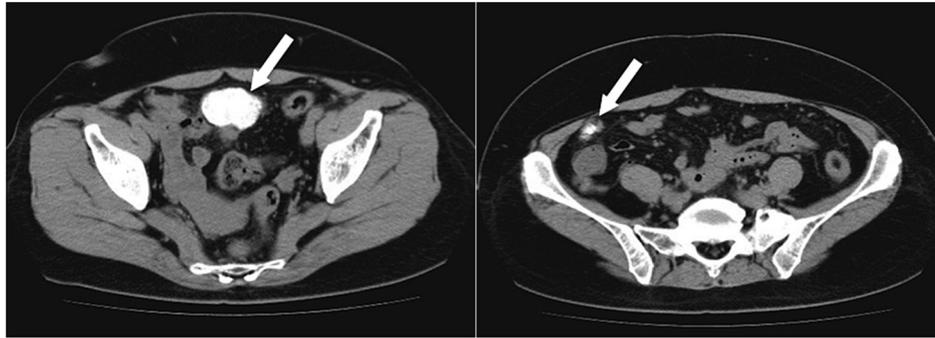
The computed tomography image shows calcific masses in the mesentery. The needle biopsy results indicated metastatic adenocarcinoma. The intraperitoneal calcific masses (arrows) measure 5.0 cm × 4.0 cm and 3.0 cm × 3.0 cm.
